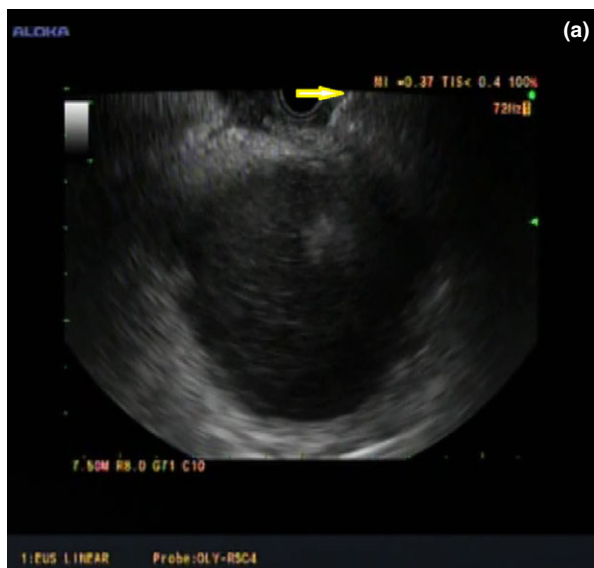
(a) Endoscopic ultrasound view of the tip of the hot AXIOS stent (Boston Scientific, Natick, MA, USA) at the wall of the infected walled-off necrosis (WON). (b) Endoscopic ultrasound view showing the inner flanges of the hot AXIOS stent opening up after insertion into the infected WON.
